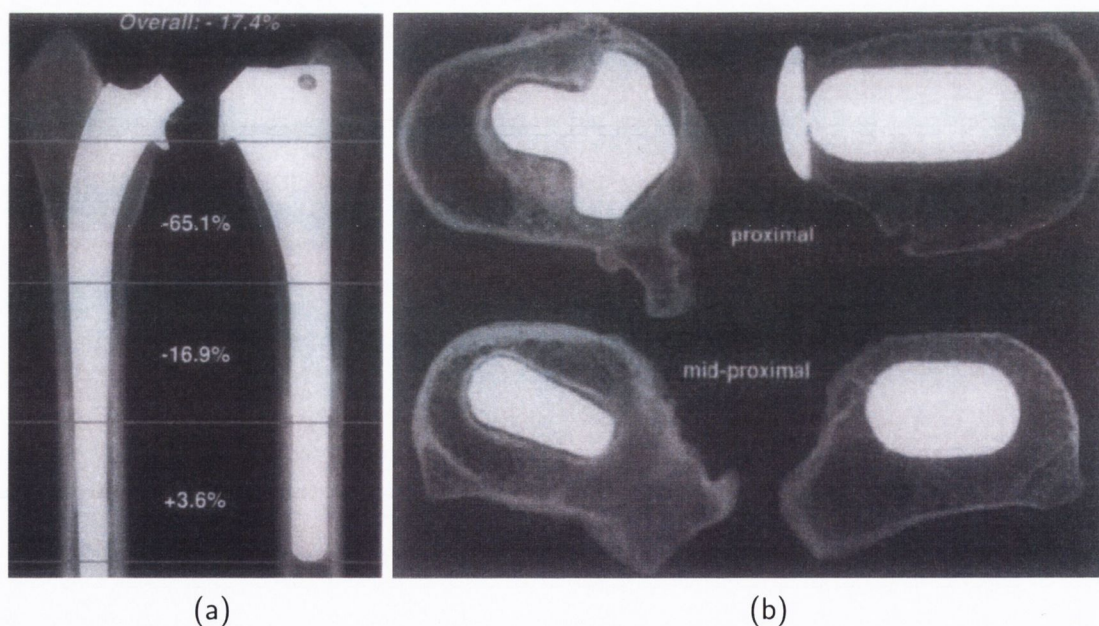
Radiographs of (a) the percentage difference in bone mineral content between the femur implanted with the stiffer stem (right) and more flexible stem (left), and (b) proximal cross sections of the femur implanted with the stiffer stem (right) and more flexible stem showing radiolucent gaps(left). Taken from Engh et al. (1999).
